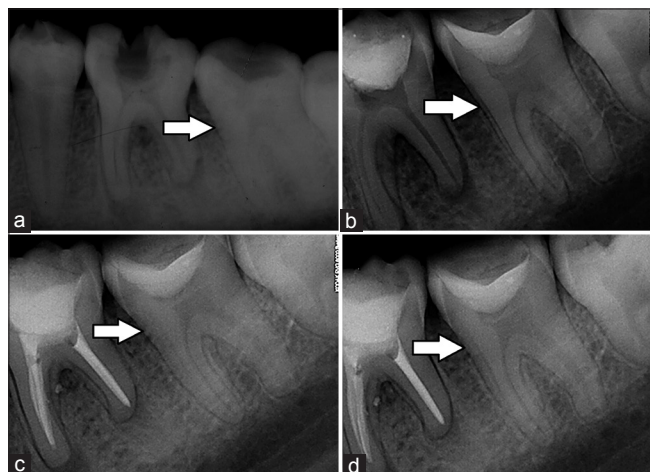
Radiographic evaluation of a case with calcium hydroxide pulpotomy (tooth #37). (a) Preoperative radiograph. (b) Immediate postoperative radiograph after performing pulpotomy. (c) Six months follow-up radiograph. (d) One year follow-up radiograph
